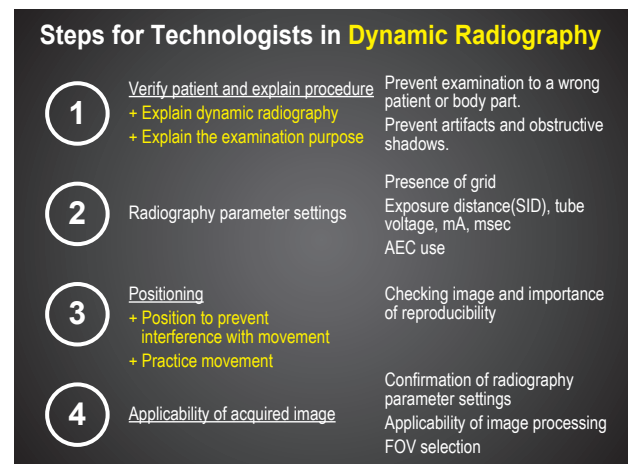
Steps for Radiological Technologists in Dynamic Radiography
